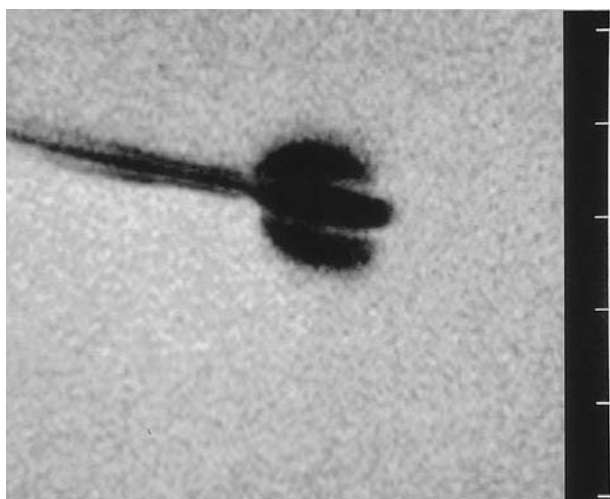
MRI artifacts caused by the Neurovent-P® ICP probe in water imaged at 1.5 Tesla using a T2*-weighted gradient-echo sequence
